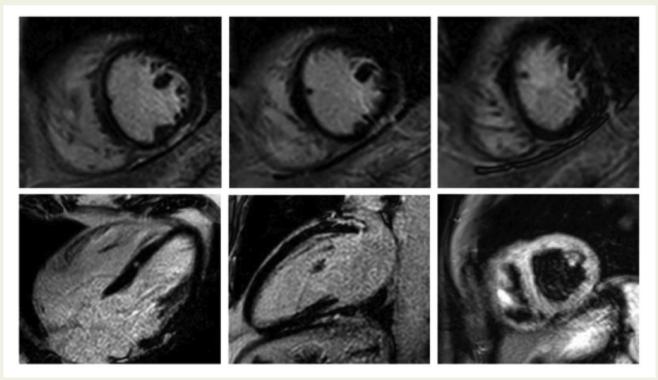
Cardiovascular magnetic resonance images from scan at follow-up, 8 months after acute event. Significant improvement seen in the extent of prior noted late gadolinium enhancement with resolution of myocardial oedema, though with residual fibrosis present. Top row (left to right): Basal SA, Mid-ventricular SA, Apical SA. Bottom row (left to right): four-chamber, two-chamber, T2 STIR.
